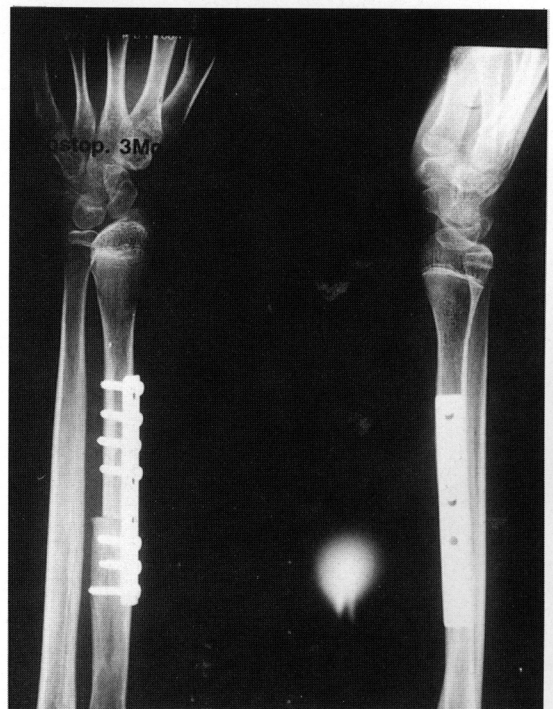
Postoperative X-ray shows reconstruction of defect with ipsilateral proximal fibula with good alignment.
